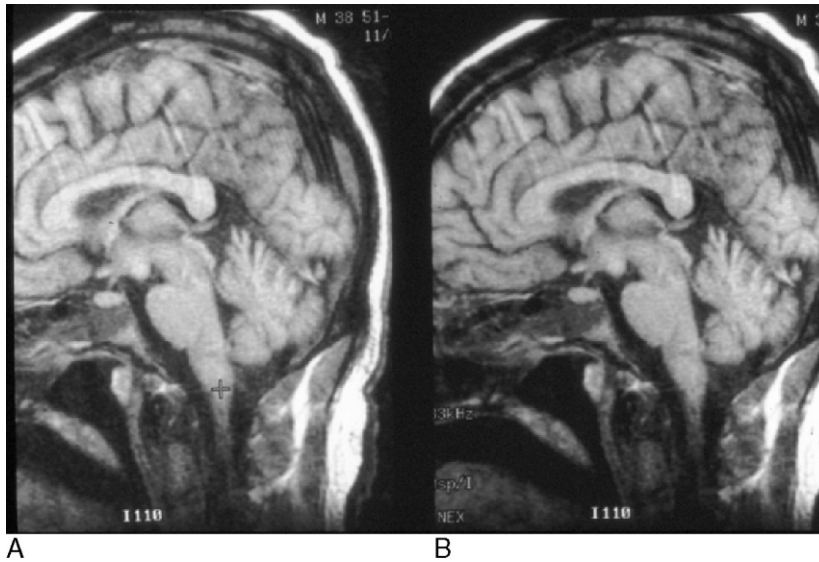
Wernicke's encephalopathy: Sagittal MRI showing hyperintense signal in mammillary body on one side.
